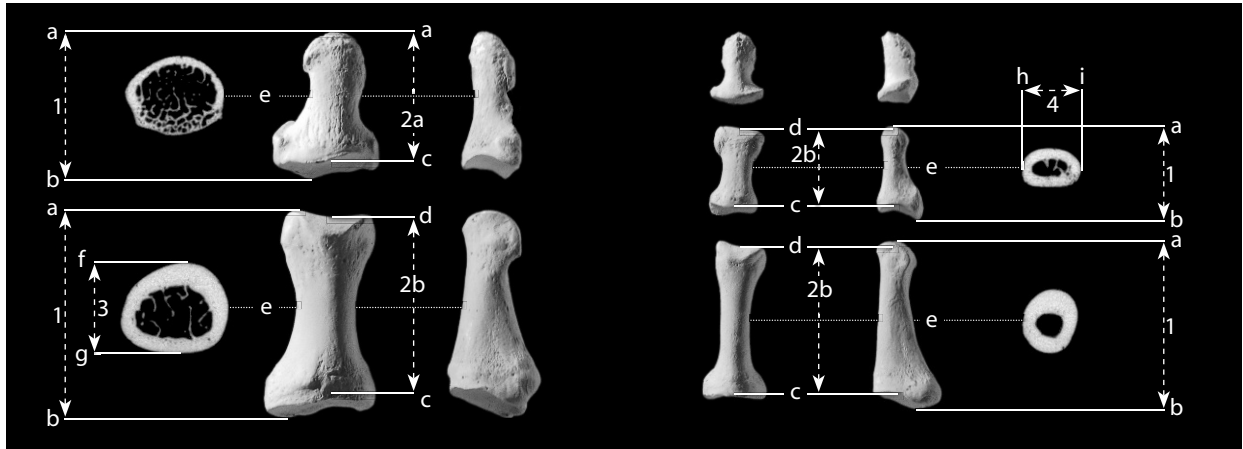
Foot phalangeal measurements. Phalanges of first and second pedal ray. Distal is up for bones; for scans, dorsal is up. Natural size (CT sections) and two-thirds natural size (bones).
